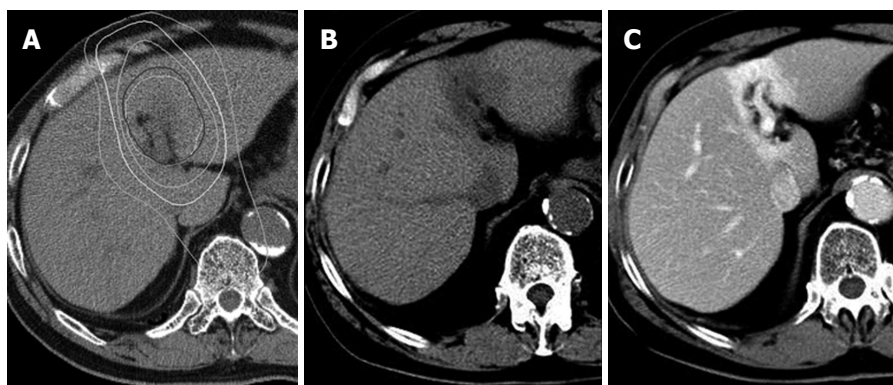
Typical focal liver reaction 3 mo after stereotactic body radiation therapy seen on computed tomography. An axial view of radiation dose distribution (A). The isodose lines (white lines) from inner to outer represent 40, 30, 20, and 10 Gy, respectively. Pre-enhancement computed tomography shows a low-density lesion corresponding to a high-dose area (B). A well-demarcated enhancement due to contrast retention indicating congestion is seen in portal phase (C).
